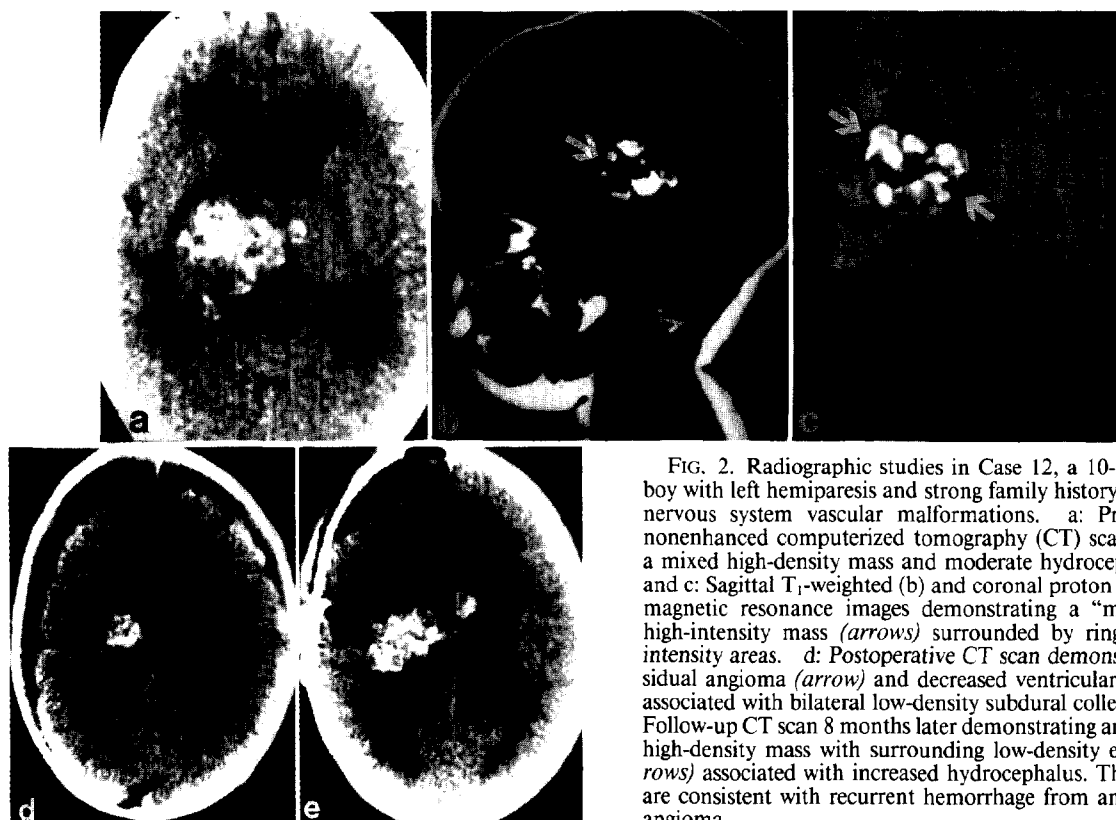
Radiographic studies in Case 12, a 10-month-old boy with left hemiparesis and strong family history of central nervous system vascular malformations. a: Preoperative nonenhanced computerized tomography (CT) scan showing a mixed high-density mass and moderate hydrocephalus. b and c: Sagittal T₁-weighted (b) and coronal proton density (c) magnetic resonance images demonstrating a "multicystic" high-intensity mass (arrows) surrounded by ring-like low-intensity areas. d: Postoperative CT scan demonstrating residual angioma (arrow) and decreased ventricular dilatation associated with bilateral low-density subdural collections. e: Follow-up CT scan 8 months later demonstrating an enlarging high-density mass with surrounding low-density edema (arrows) associated with increased hydrocephalus. The findings are consistent with recurrent hemorrhage from an enlarging angioma.
